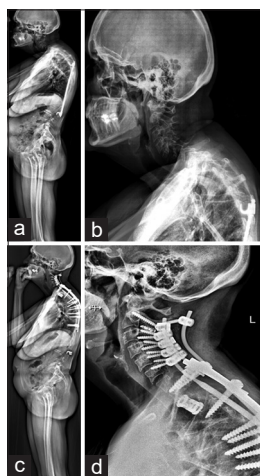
Pre- (a and b) and post-operative (c and d) full-length standing and cervical lateral radiographs of a patient with baseline hyperlordosis (C2–C7 Cobb angle = 39.0°). By 1Y, cervical malalignment was still present, with cervical sagittal vertical axis = 86.8 mm and offset of T1 slope minus cervical lordosis = 56.6°
